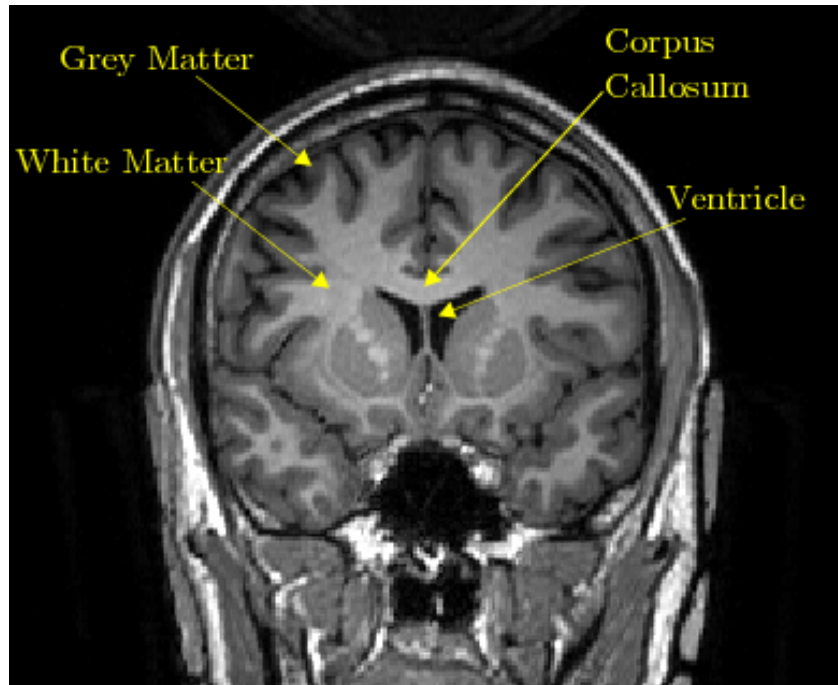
A MRI image of brain showing regions of white matter, grey matter, the Ventricles and the Corpus Callosum. The latter is the largest white matter structure in the brain and consists of 200-250 million contralateral axonal projections.
